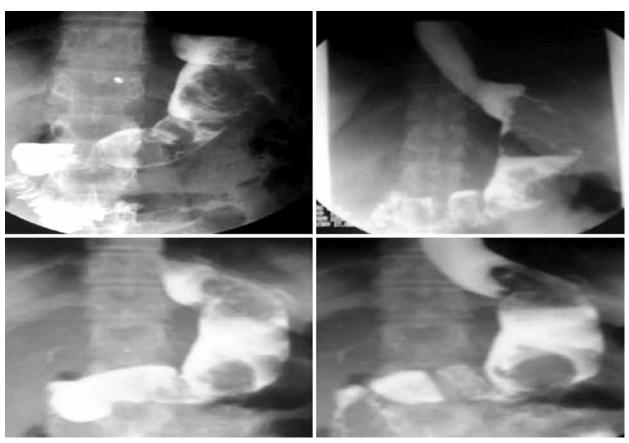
Postoperative gastrografin meal X-ray (normal gastrografin meal at day 1)
